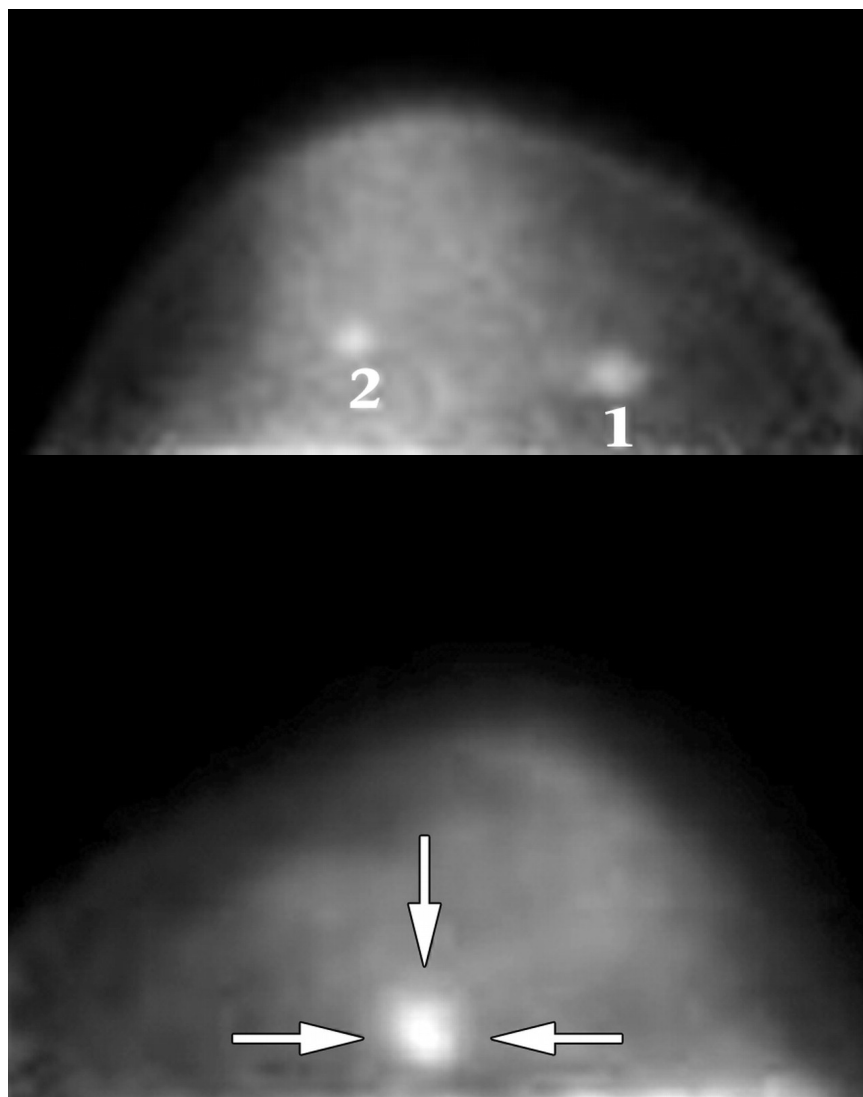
(a) Transverse FDG PET image demonstrating two abnormalities. Lesion 1 represents invasive carcinoma that was depicted at conventional mammography while lesion 2 represents a noninvasive papillary carcinoma, which was not visible at conventional mammography. (b) Transverse PET image of the left breast depicts a single focus of increased FDG activity (arrows) at the site of the mass¹¹⁰.
